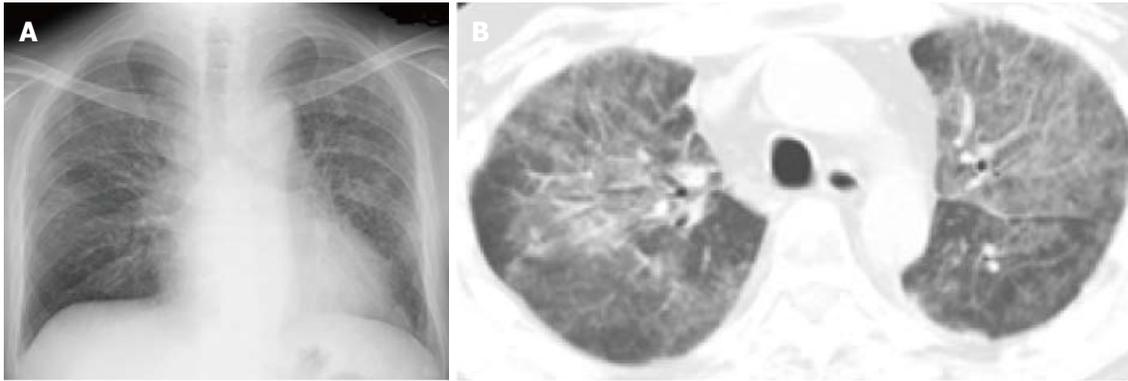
Pneumocystis jirovecii* pneumonia in a man in his 20s. A: Chest radiograph shows bilateral reticulonodular opacities; B: Chest computed tomography with a 5 mm slice thickness demonstrates bilateral ground-glass opacity with reticulations.
